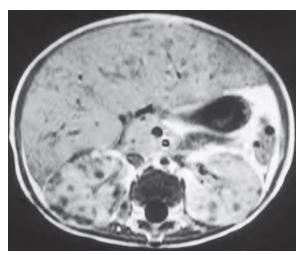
Candida abscess in the liver, kidney, and spleen on magnetic resonance imaging.
